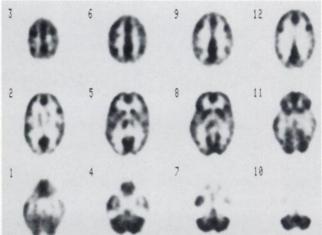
FDG study with the NeuroECAT tomograph. This interictal study of a partial epilepsy patient is displayed with the subject's right on the images' right. Both investigators reported right mesial temporal, lateral temporal and thalamic hypometabolism.
